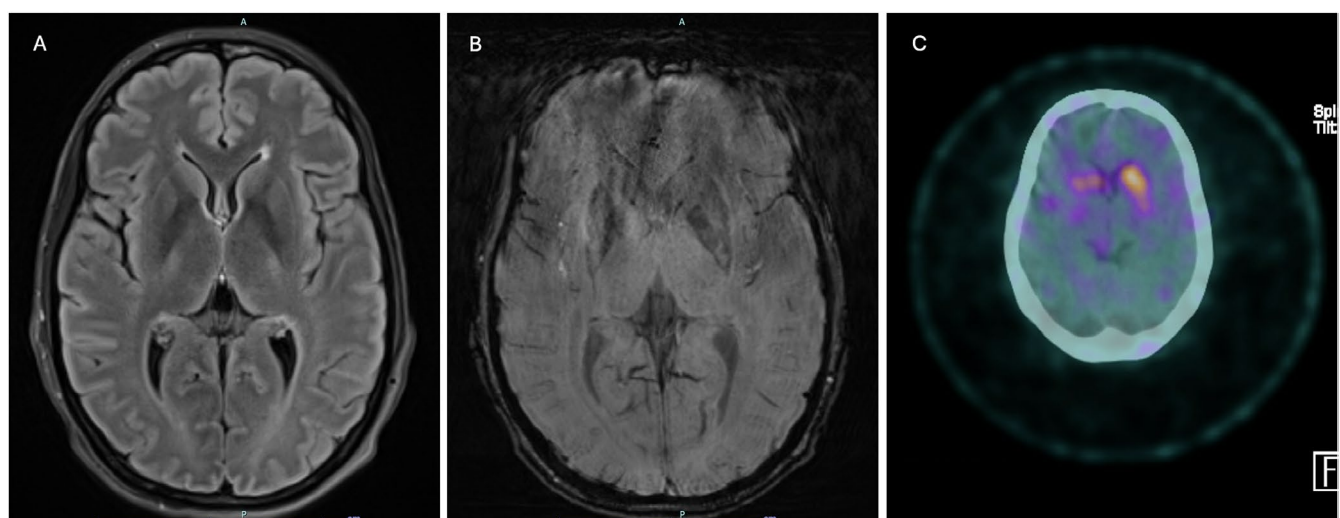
Neuroimaging. (A) Axial FLAIR MRI: Non-specific T2 signal shortening in the globi pallidi and lateral putamina. (B) Axial susceptibility-weighted imaging (SWI): Increased susceptibility in the corresponding regions, without “eye-of-the-tiger” sign or extensive iron overload. (C) Dopamine transporter (DAT) SPECT: Asymmetrically reduced striatal uptake in the putamina (right greater than left), consistent with presynaptic nigrostriatal dysfunction and correlating with the patient’s left-sided symptom predominance.
